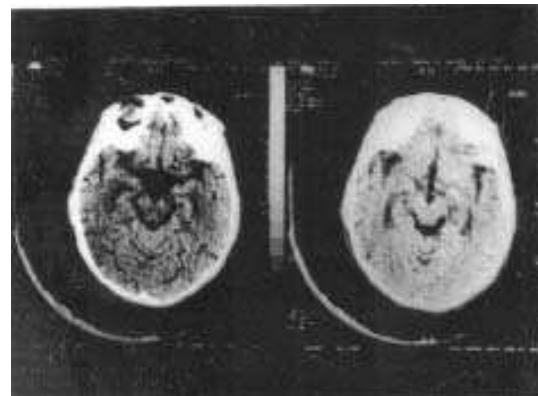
Patient no. (5): Normal CT scan.
